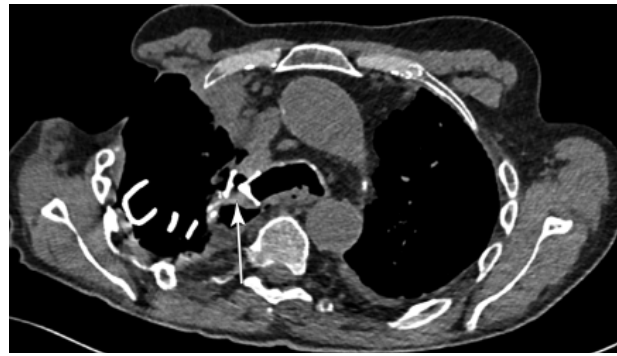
Post-procedural chest CT confirming correct positioning of the Amplatzer occluder in the right upper lobe bronchial stump (Case 1)
